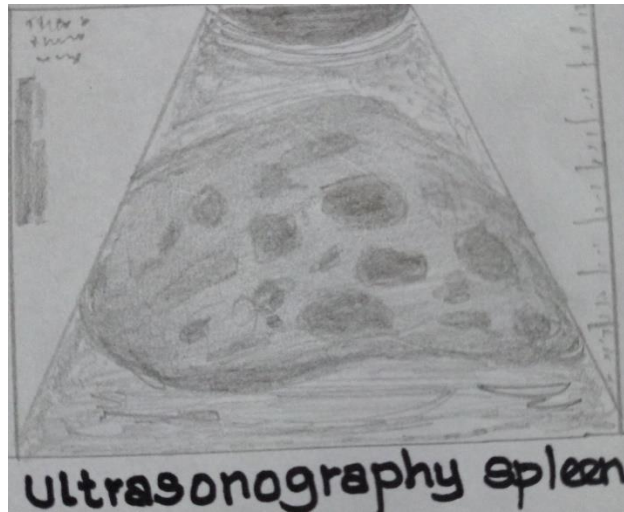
b-Ultrasonography. Splenic-involvement
